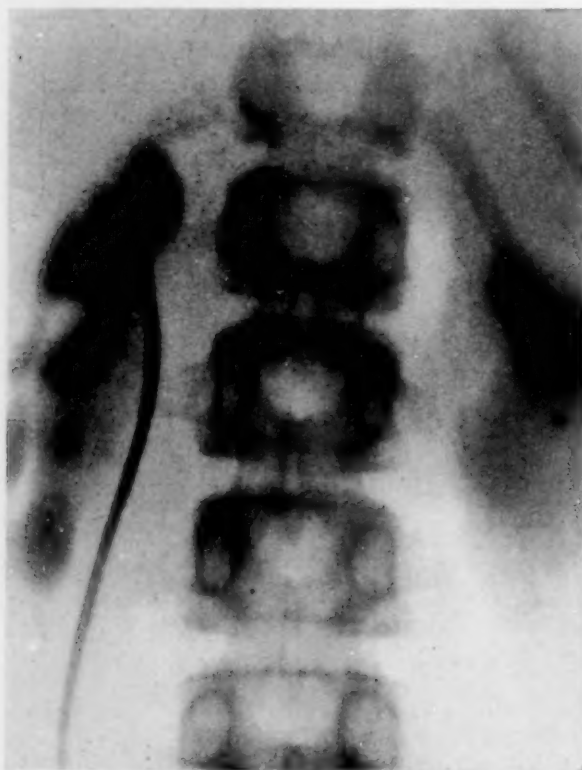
Faulty insertion at uretero-pelvic junction. No. 28860. Female, ten years, July 15, 1920. Uretero-pyelograms show advanced bilateral hydronephrosis. Greatly delayed emptying time of pelvis. Radiographic appearances suggest a faulty insertion of the ureter into the renal pelvis. Not confirmed by operation.
